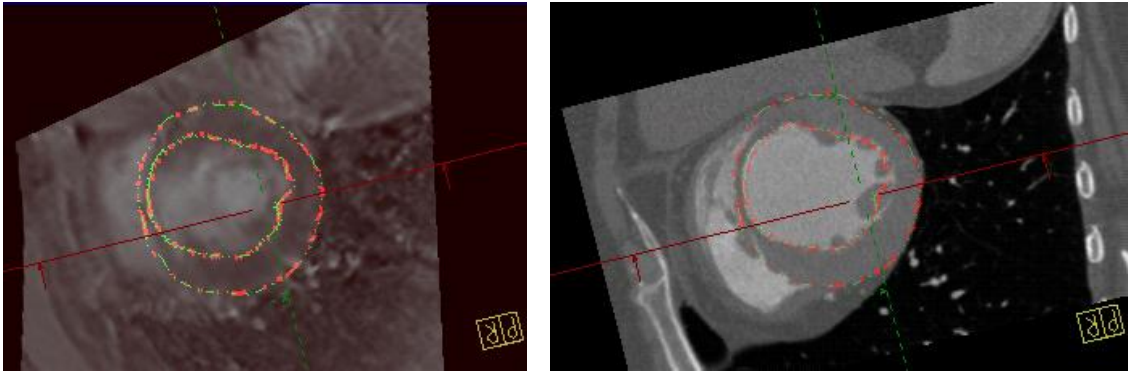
Registration result for Patient 1. DEMR images (a), CTA volume (b) and overlay of both in the short axis view (c).
